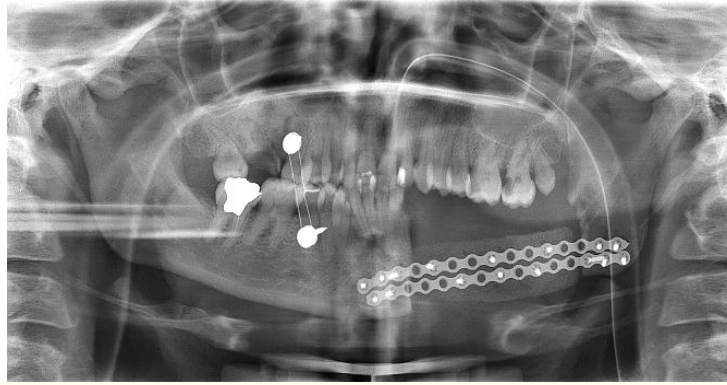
Panoramic radiograph shows partial mandibulectomy and mandibular reconstruction using a bridging plate.
